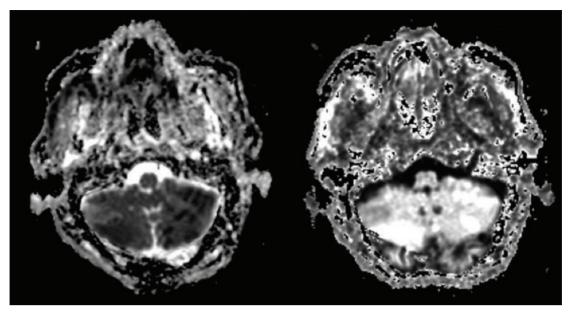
Magnetic resonance imaging of Case 2
